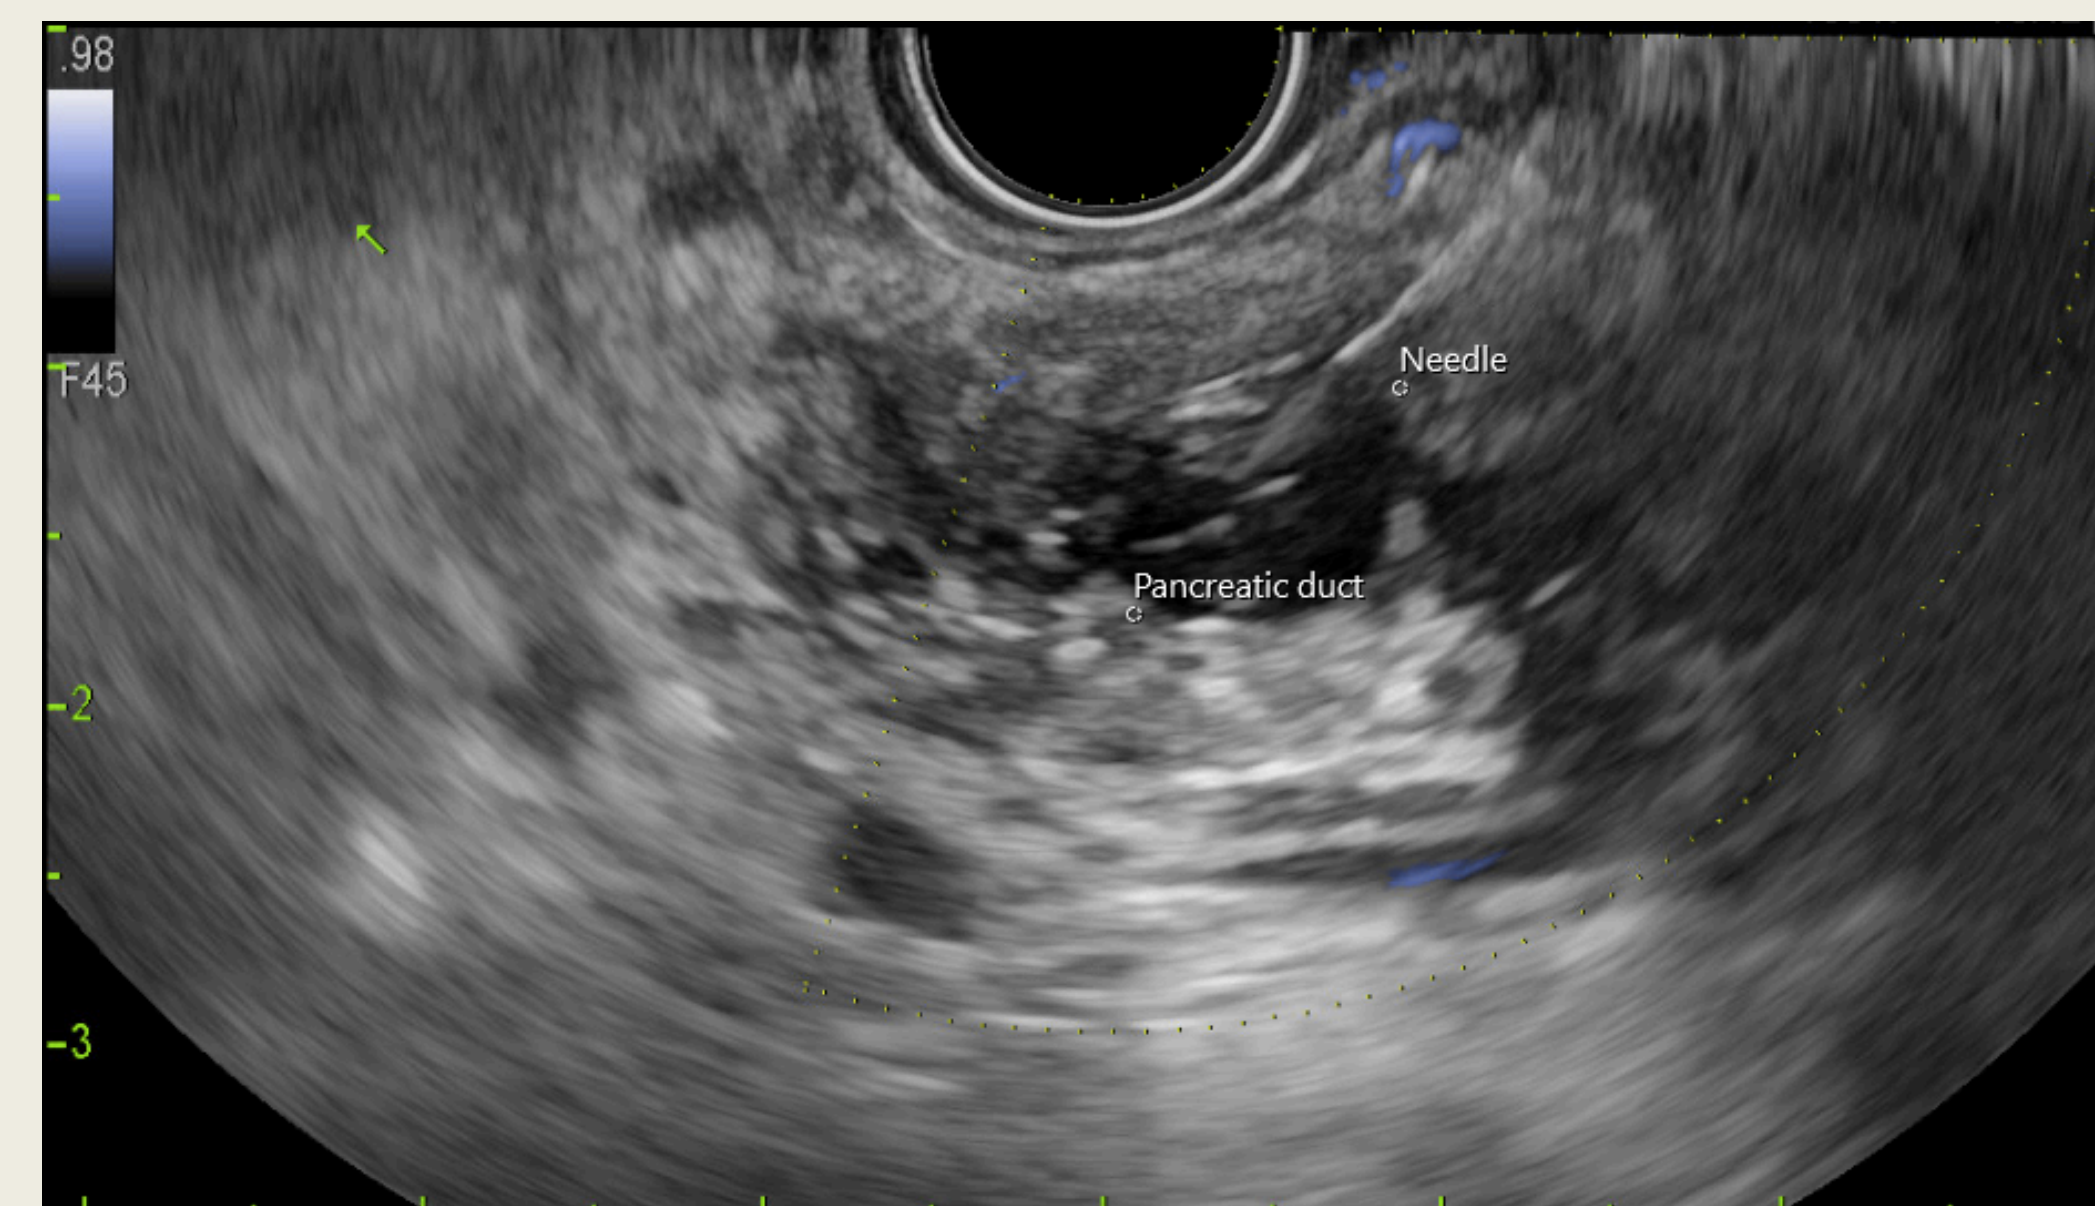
Cannulation of PD through the stomach under ultrasonography
